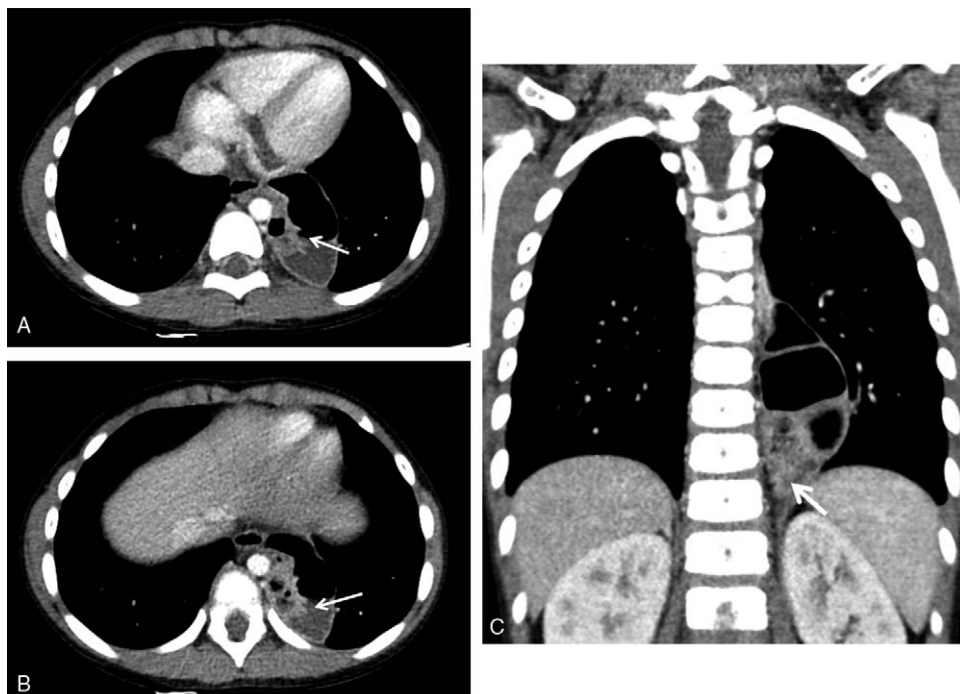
Computed tomography images (A, B) axial, (C) coronal planes of a mediastinal cyst in a 6 year-old child. Note that the cyst with its inner circular fold and double-layered enhancement suggests a bowel-like cystic lesion (arrows).
